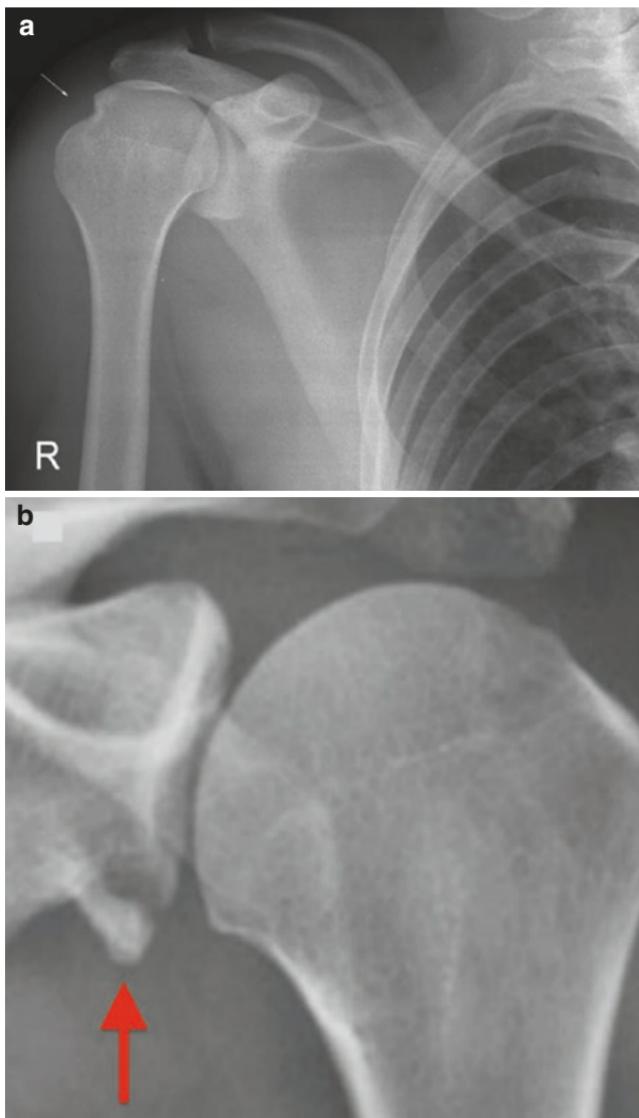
Shoulder X-ray: (a) Hill-Sachs lesion. (b) Bony Bankart lesion. (a: Used with permission from: <http://www.wikiradiography.net/page/Hill-Sachs+and+Bankart+Lesions>. b: Reprinted from Jaeger M, Izadpanah K, Südkamp NP. Posttraumatic shoulder instability. In: Oestern HJ, Trentz O, Uranues S, editors. Bone and joint injuries. European manual of medicine. Berlin/Heidelberg: Springer-Verlag; 2014. p. 13–23. With permission from Springer Nature)
